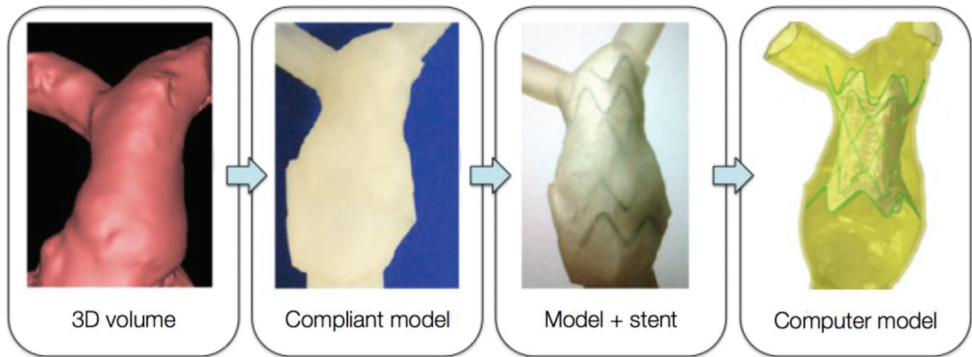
Reconstruction of patient-specific right ventricular outflow tract from CT data ('3D volume') which is 3D printed using a compliant rubber-like material ('compliant model'); a stent is inserted inside the 3D model for testing ('model + stent') and additional data can be acquired by replicating the 'model + stent' system computationally. Stent diameter at extremities = 40.7 mm.
